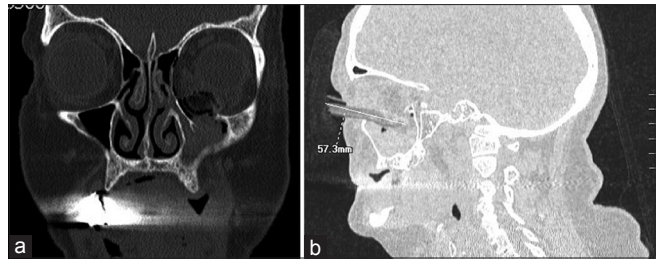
(a) Preoperative computed tomography image with coronal section showing a defect in the orbital floor, (b) sagittal section showing details of the foreign body
